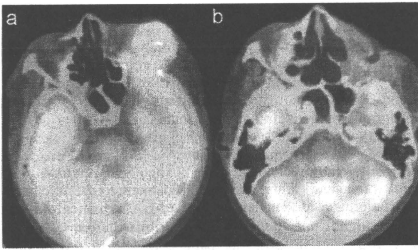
(A) FDG-PET study in case 22 prior to BNCT. FDG tracer was accumulated in the left orbital region (arrow heads) and frontal lobe of brain. (B) 6 months after BNCT. No accumulation of FDG-PET was recognized 6 months after BNCT.
